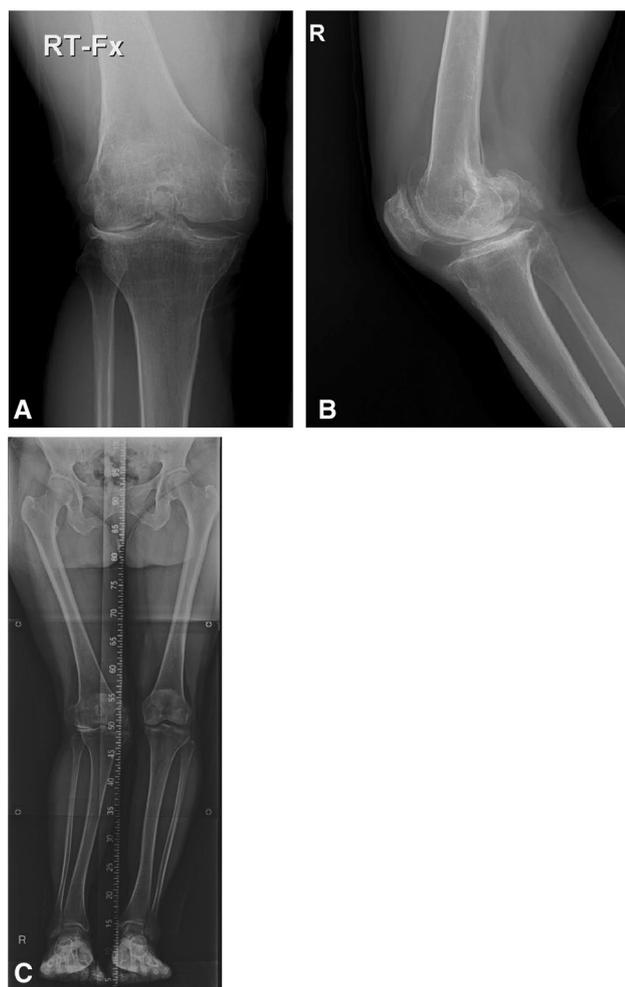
Radiograph right knee. Anteroposterior (a) and lateral view (b). c Scanogram lower limbs showing lateral mechanical axis deviation and valgus
